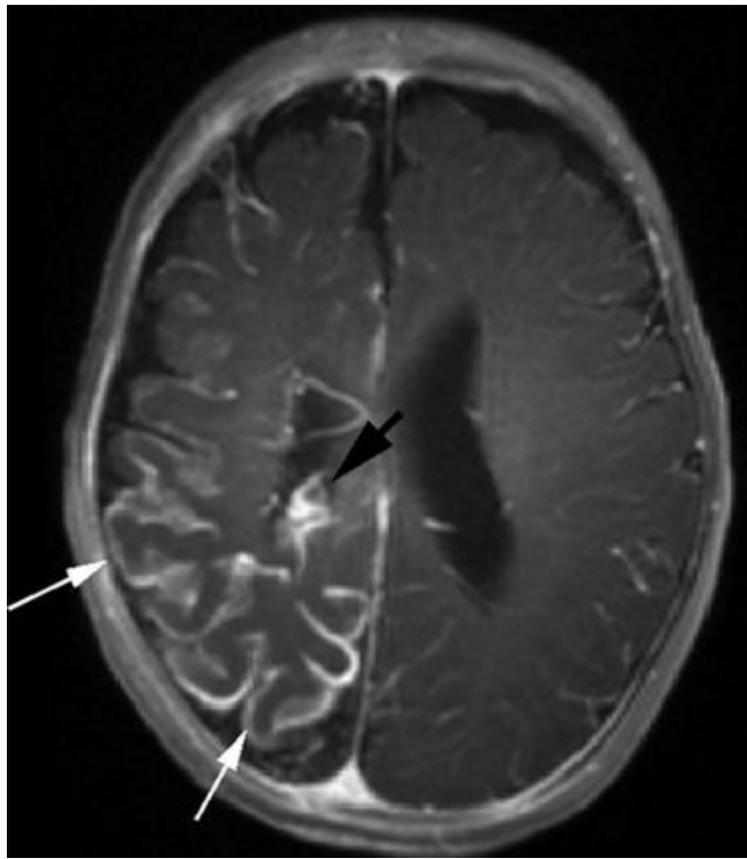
Sturge–Weber syndrome. Axial MPRAGE image from MRI with gadolinium in a 12-month-old girl with left tonic-clonic seizures shows diffuse gyriform enhancement (white arrows) with enlargement of the glomus of the right choroid plexus (black arrow).
